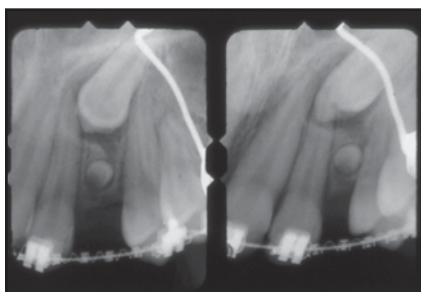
(left) Preoperative radiographs, taken using the standard parallel cone technique (left) and in a mesial angulation (right). Using the SLOB rule, the tooth was found to be located palatally.
